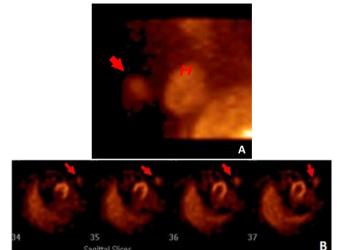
A: Tc-99m MIBI scintigraphy raw image indicating focal uptake in the lateral superior quadrant of the left breast (H: heart) (Arrow). B: Tc-99m MIBI scintigraphy sagittal sectional images with focal uptake in the left breast (Arrows).
